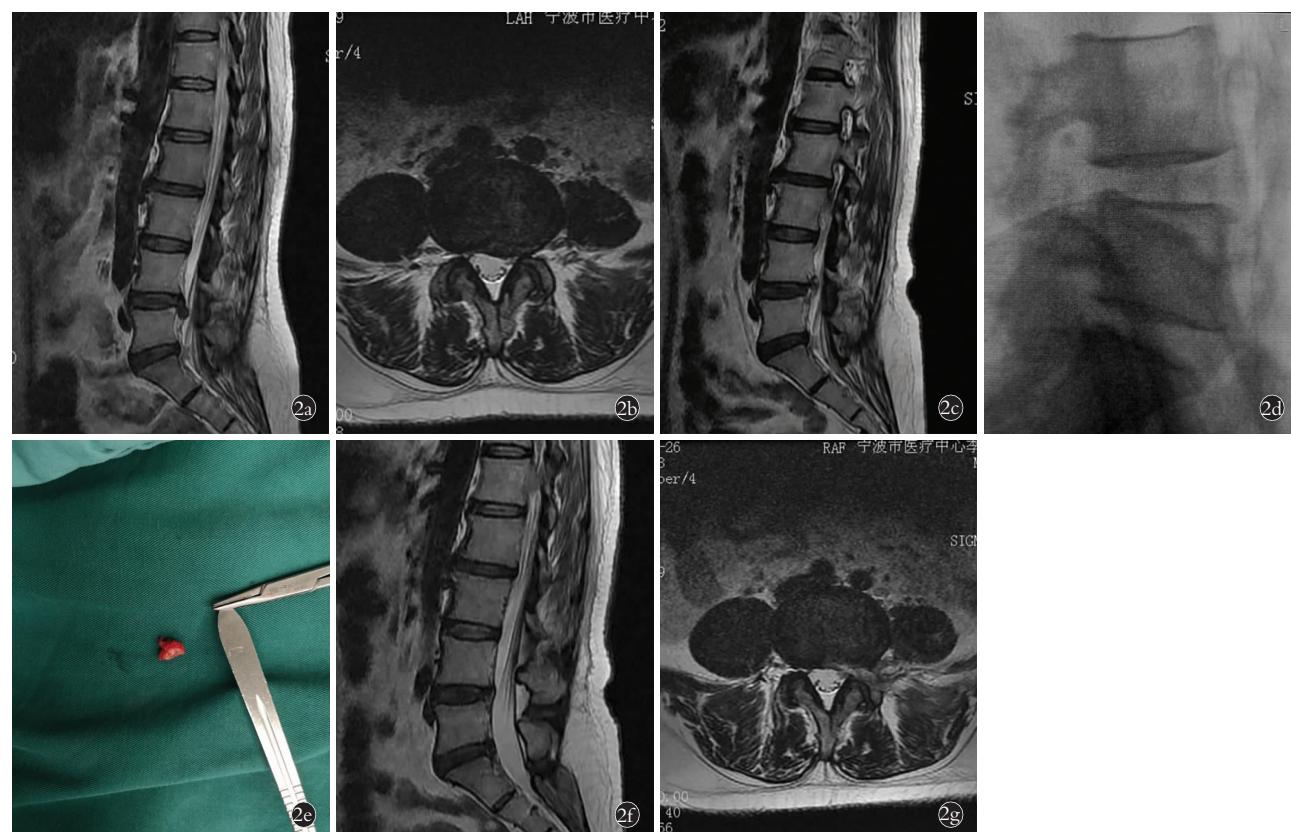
女性患者,43岁,因右侧腰腿痛 1 周入院,诊断为腰椎间盘突出症 2a,2b.术前 MRI 矢状面及轴状面提示 L_{4,5} 椎间盘游离向下脱出 2c.脊柱内镜术后第 2 天复查 MRI 矢状面提示 L_{4,5} 右侧椎间盘上缘骨块 2d.术后第 3 天二次手术透视 L₄ 椎弓根下缘骨块 2e.二次手术中取出碎骨块 2f,2g.二次手术后第 2 天复查 MRI 矢状面及轴状面示脊髓及神经根无受压
